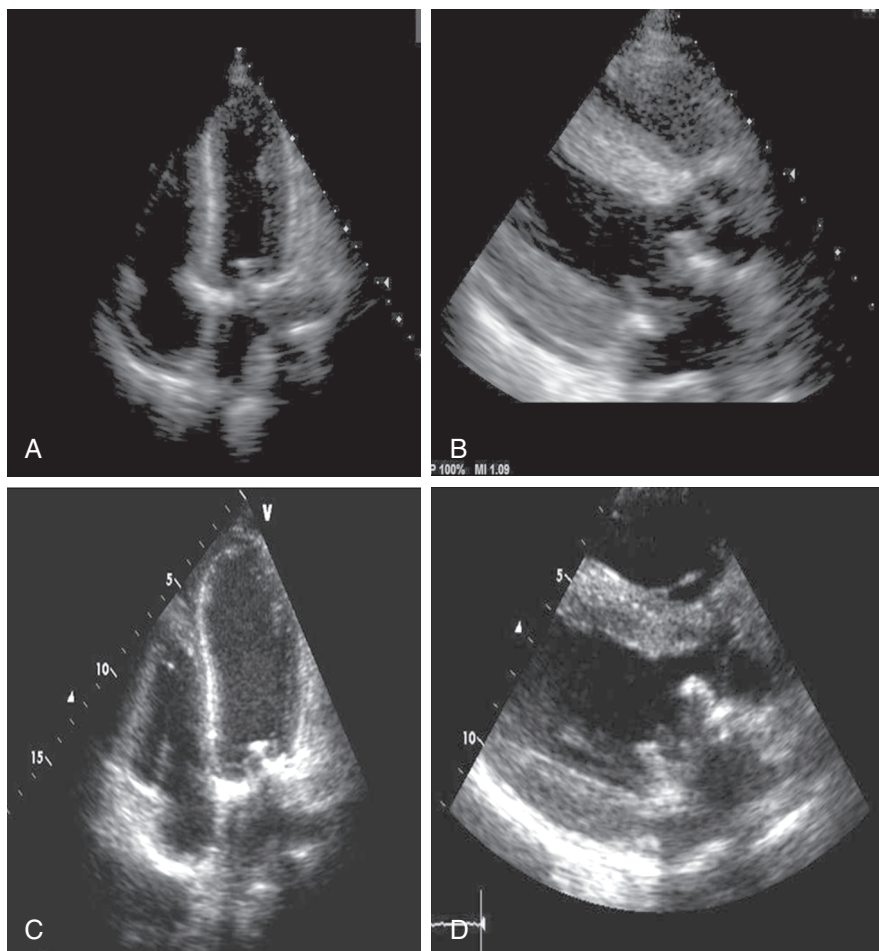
Myocarditis in SLE. A and C, Four-chamber view, B and D, Left ventricular view. In a 20-year-old patient with dyspnea and active SLE, the initial echocardiogram (A and C) showed mild impairment of ventricular function. Following symptomatic deterioration, the echocardiogram was repeated 6 days later and demonstrated markedly increased thickening of the left ventricular wall with a bright signal suggestive of inflammatory infiltration. These findings were associated with substantial deterioration in left ventricular function.
